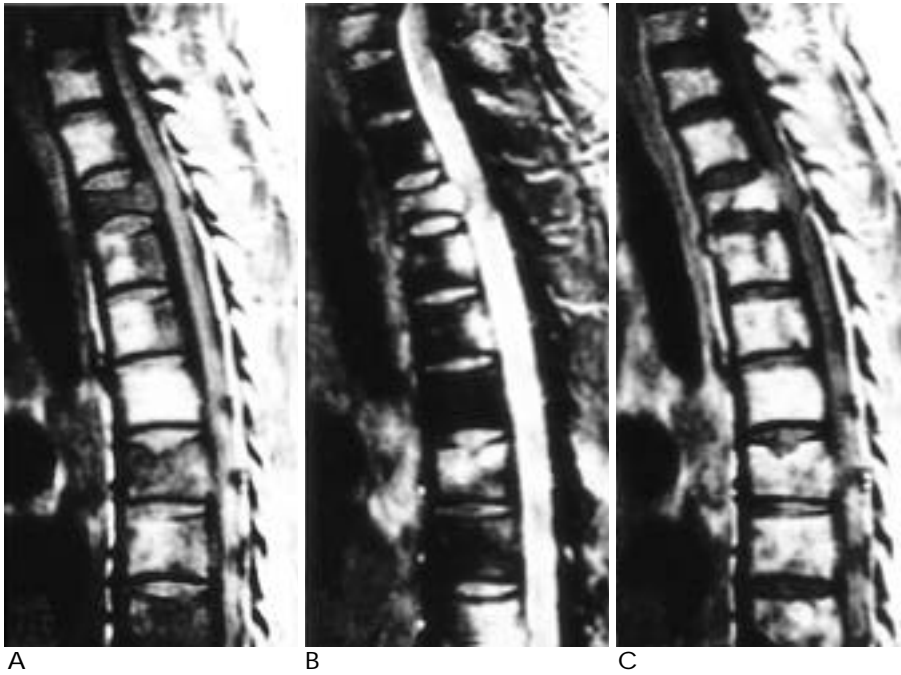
Metastasis from lung cancer appearing as a focal pattern of marrow involvement in 66-year-old man. A, B, C. Multiple variable sized, poorly defined masses are seen in (A) T1-weighted, (B) T2-weighted, and (C) T1-weighted postcontrast sagittal MR images.
